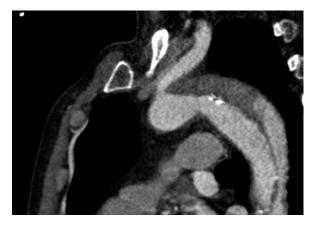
Computed tomographic angiography (CTA) of the thoracic aorta showing a type B dissection, sagittal view.
